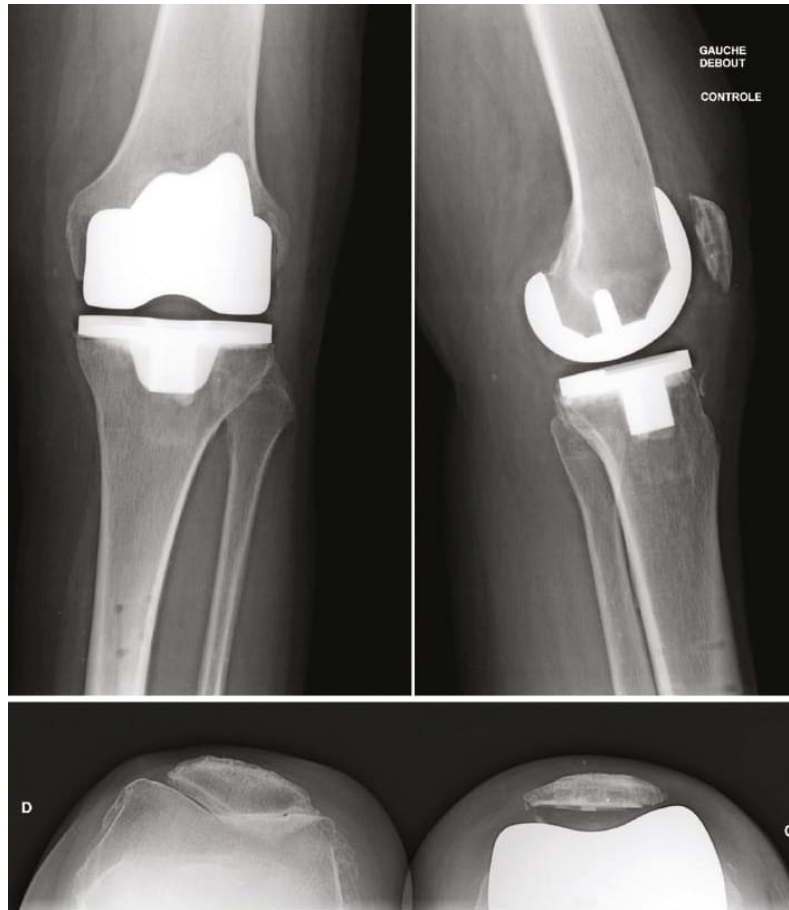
Example of radiographic assessment at 1 month.
